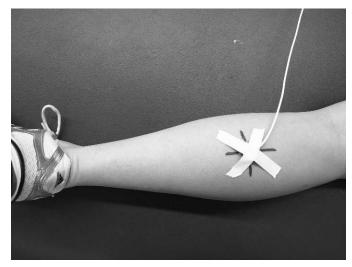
Crosshair design and positioning for laser Doppler probe (LDF 100C; Biopac Systems, Inc, Goleta, CA).
